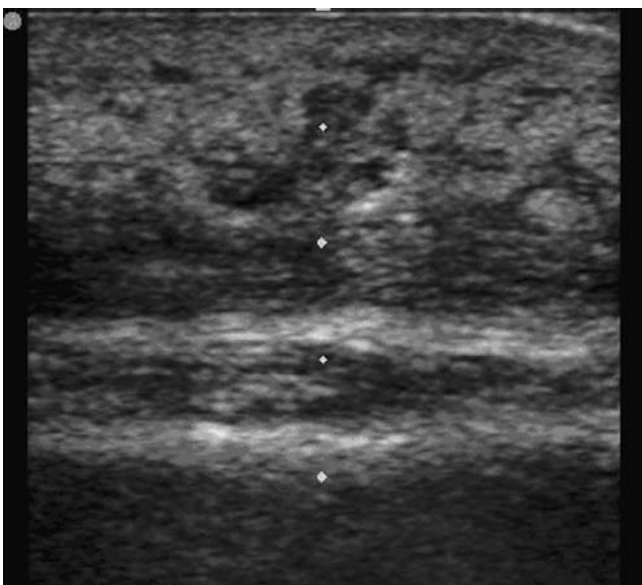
Ultrasound of inflamed skin with “cobblestone” appearance.
